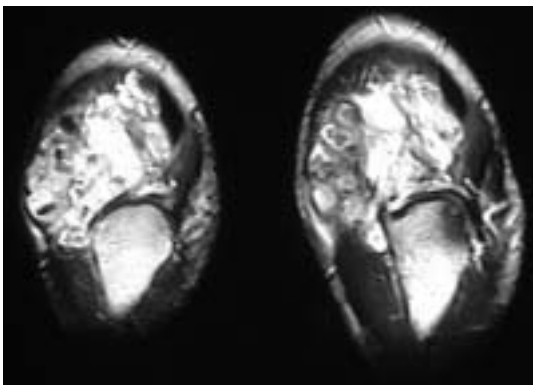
Axial T2-weighted fat-suppressed fast spin echo sequence demonstrating foci of low signal intensity within the predominately intermediate signal mass corresponding to similar areas on the T1-weighted image
